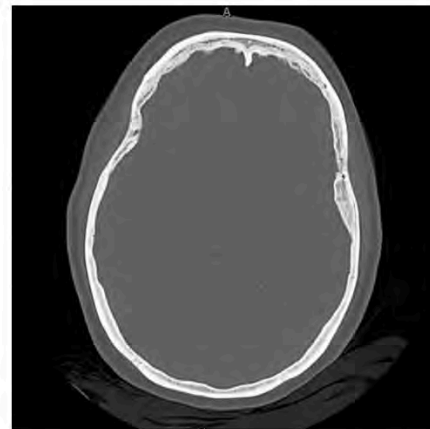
brain CT showing resolution of the pneumocephalus 5 days after initial CT in figure 1.
